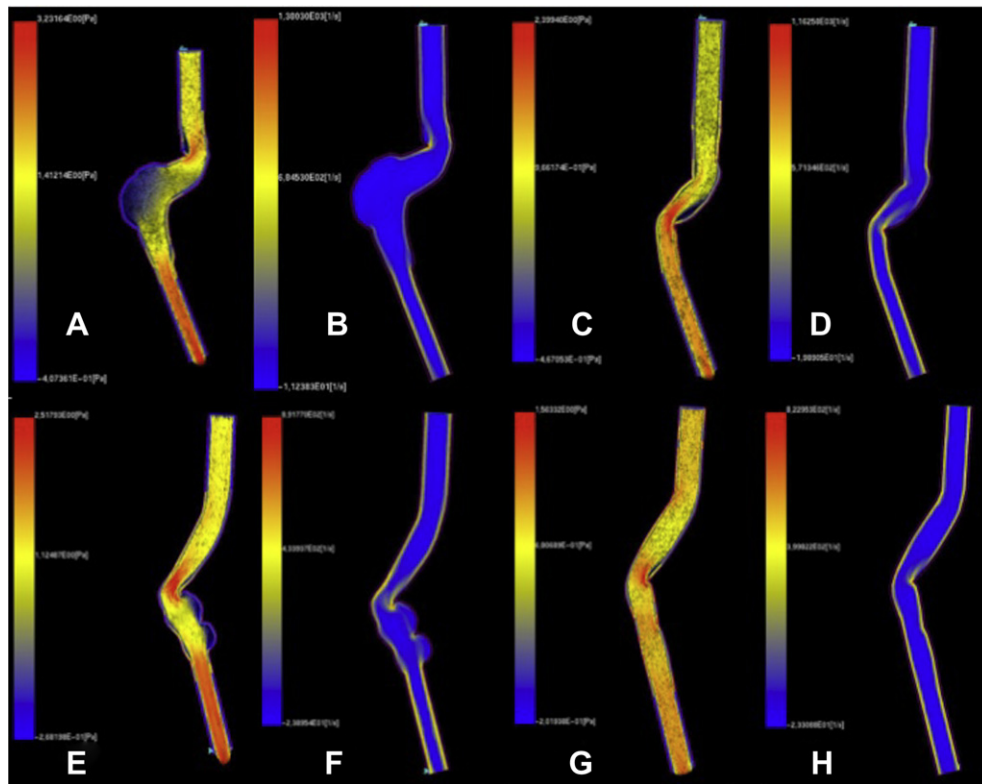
Bidimensional computer models of abdominal aortic aneurysms (AAAs) were built from angio-computed tomography (CT) scan data. Each angio-CT image was coupled with a computational fluid dynamics evaluation performed using an open source software (CSC Elmer, <http://www.elmerfem.org/>; ElmerSolver, CSC Institute of Technology, Espoo, Finland). Images of cases 1 (A-D) and 2 (E-H), showing both anatomic and hemodynamic remodeling after endovascular repair.
